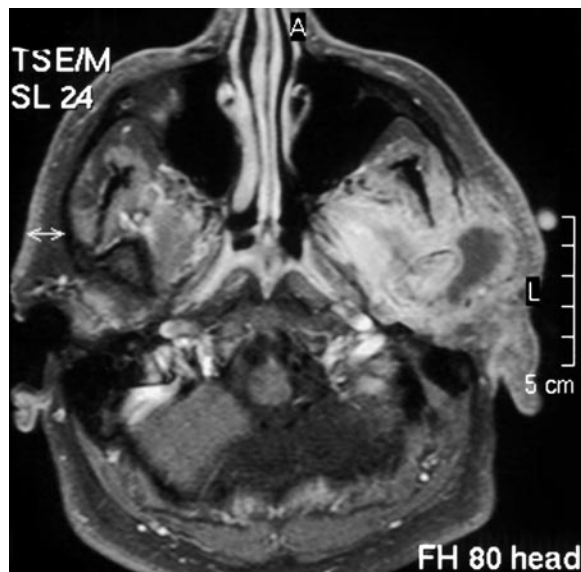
Secondary chronic osteomyelitis of the left temporomandibular joint: Axial MRI scan demonstrates an abscess in the left preauricular region (hypointense area) surrounded by diffuse tissue infiltration (hyperintense area) involving the left lateral pterygoid muscle. (This case is described in detail in Chap. 12, case report 12)
